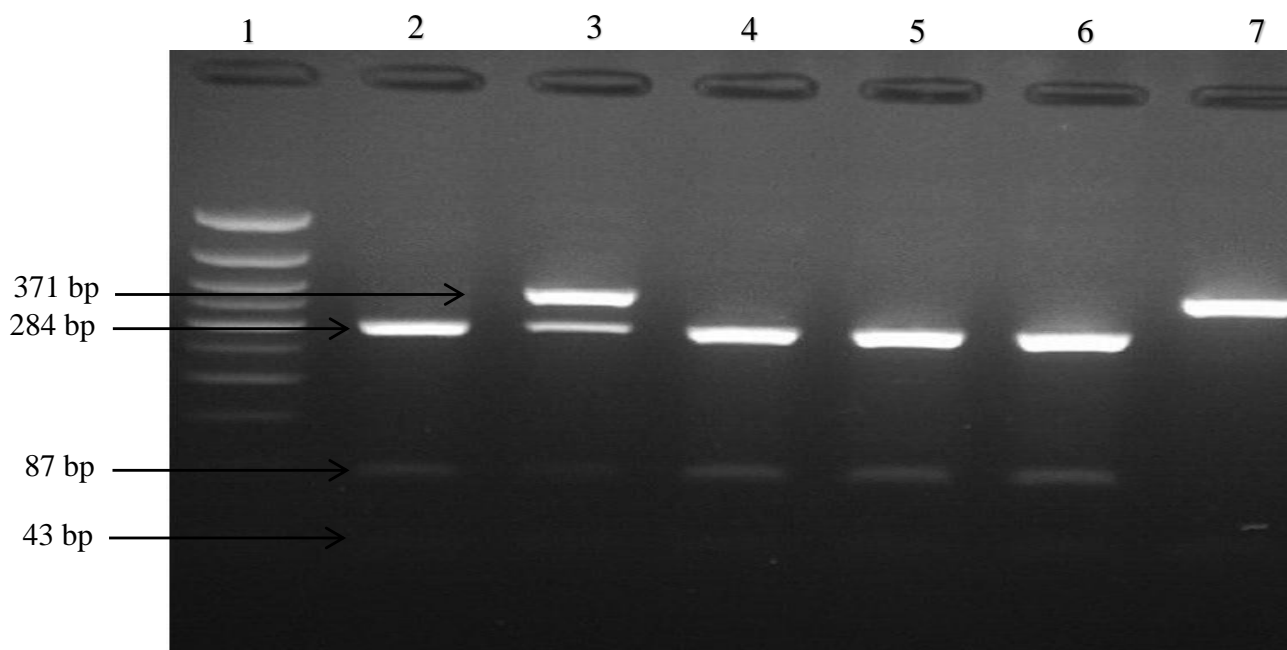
Effect of Msp1 enzyme on PCR products of rs2237892 polymorphism. 50 bp ladder was used. C allele shows 284, 87 and 43 base pair bands, T allele has 371 and 43 base pair bands: lane1= DNA ladder, lane2,4,5,6= CC, lane3= CT, lane7= TT
